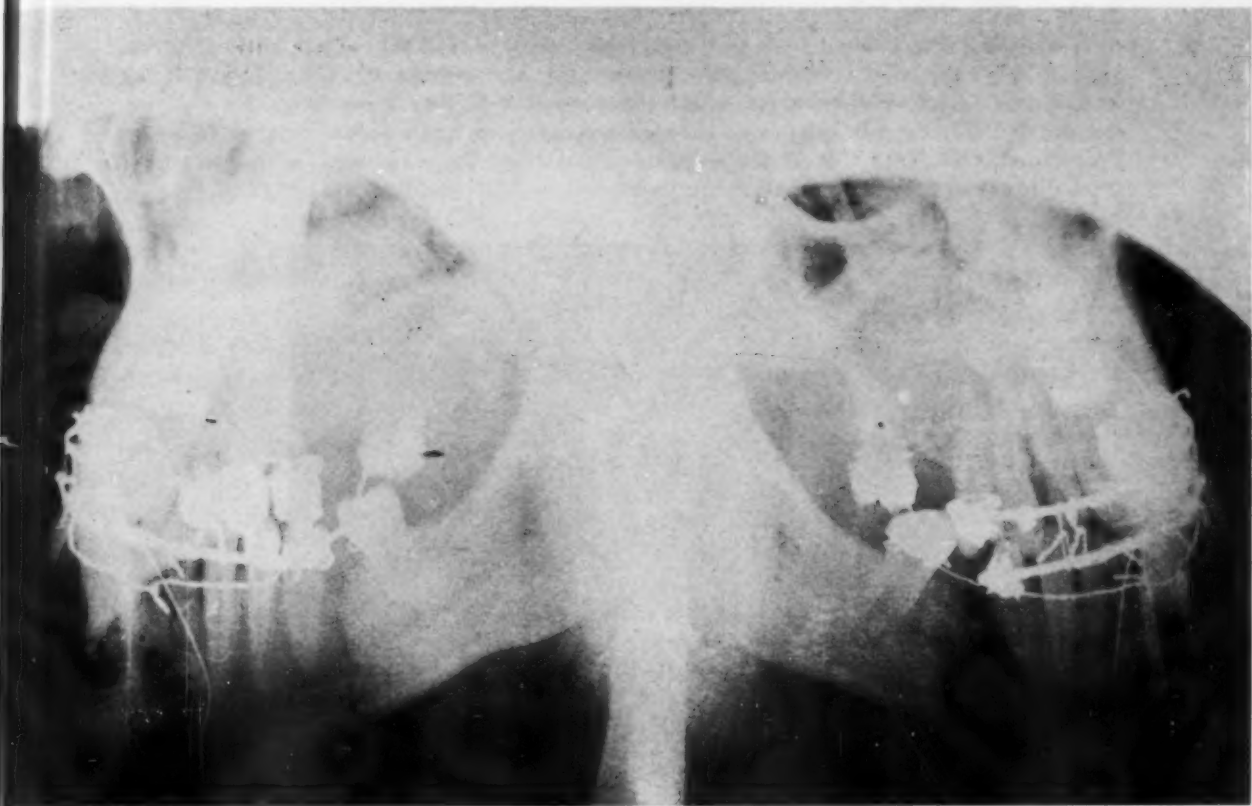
Case 3. Postoperative radiographs showing relationship of fragments.
